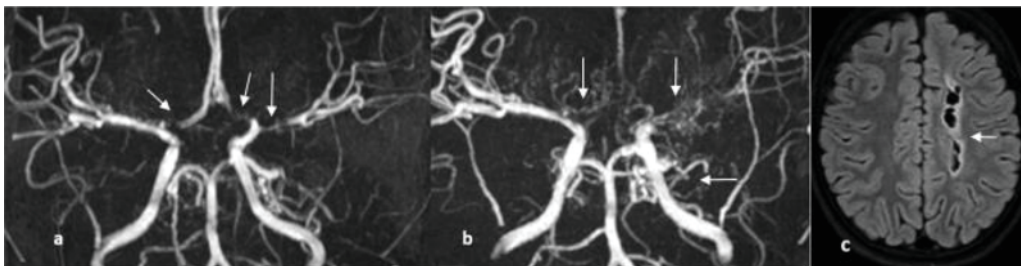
SCA patient who suffered a stroke at the age of 3 years. A 3-year severe narrowing of proximal right and left ACAs and left MCA. (b) At seven years of age, occlusion of left MCA and both ACAs and extensive bilateral lenticulostriate perforator collaterals and left cerebellar collaterals (arrows) suggestive of a Moya network. (c) At seven years of age, FLAIR axial view. Sequelae of the left internal borderzone infarct.
